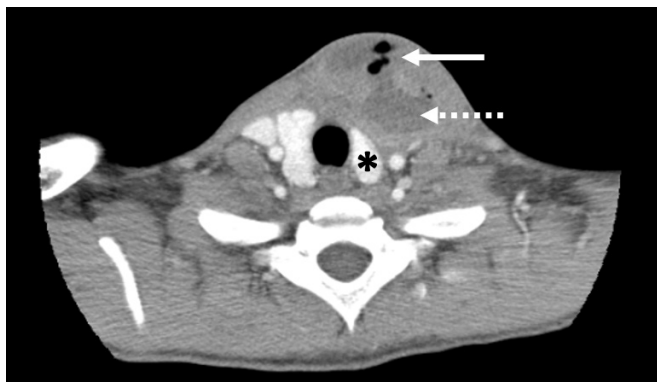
Overinfected fourth branchial remnant with large cervical abscess in CT scan. Gas content within the fluid collection (solid arrow). Liquid content within the fluid collection (dashed arrow) in proximity to the left thyroid lobe (asterisk).
